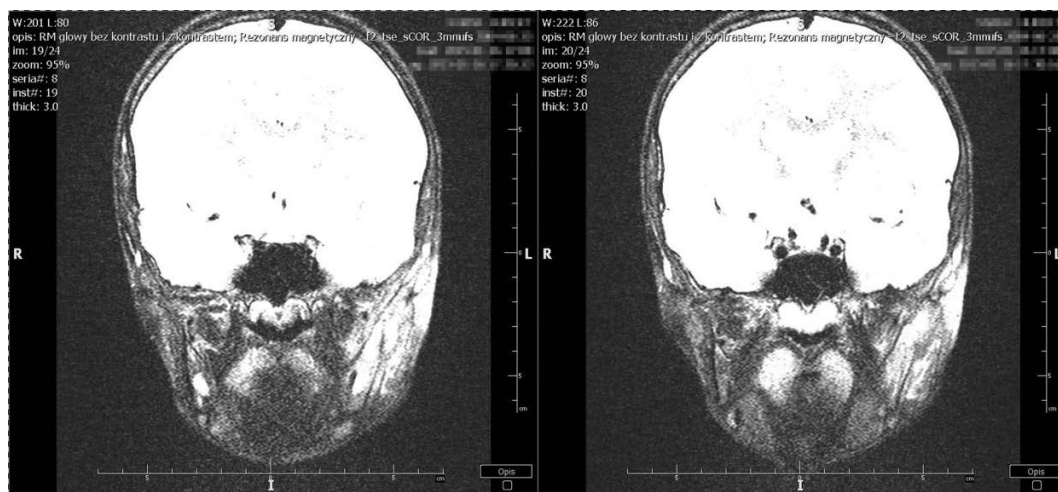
MRI – a ruptured cortical bone layer in the mandibular branch with infiltration of the myeloid cavity, the lesion involves the masseter and the lateral portion of the lateral medial pterygoid
